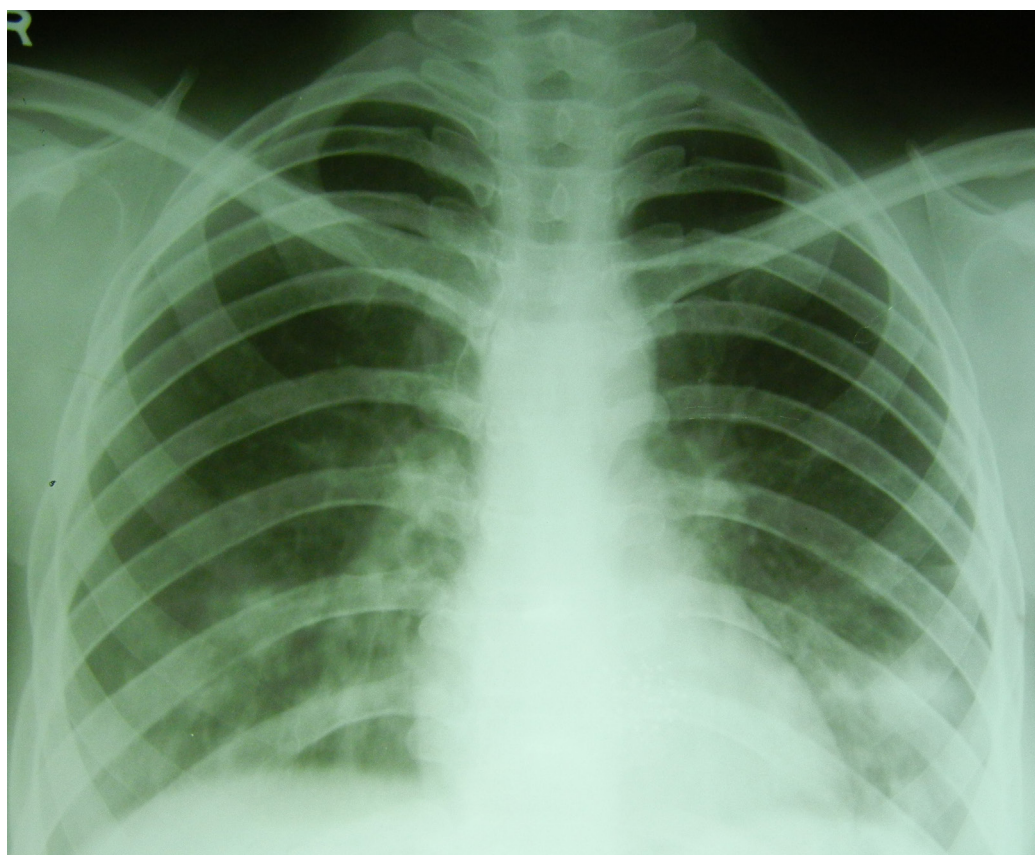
Chest radiograph showing progressive increase in opacities bilaterally in the mid and lower zones.
